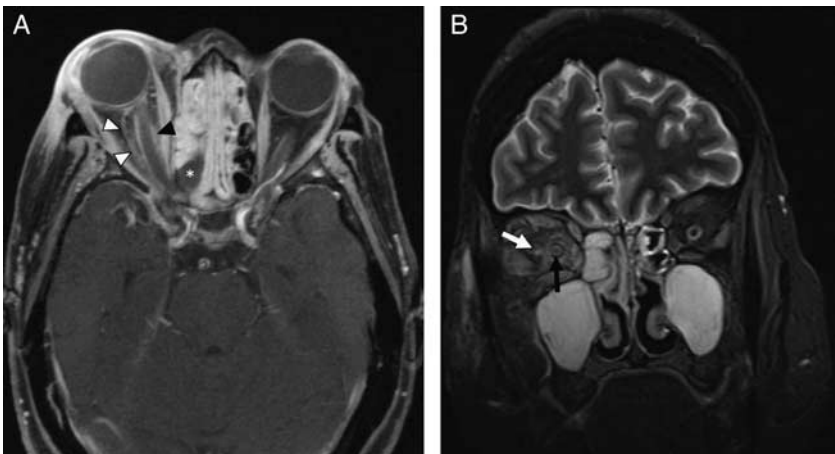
60-year-old woman with CLL was admitted for febrile neutropenia developed right eye chemosis, periorbital edema, and proptosis. She was taken urgently for orbital extenteration, which revealed invasive fungal disease. Axial T1-weighted contrast-enhanced fat-saturated MRI (A) demonstrates absent enhancement of a right posterior ethmoid air cell (white asterisk) as well as heterogenous enhancement of the right optic nerve sheath (black arrow head) and intraconal fat (white arrow heads). Coronal T2-weighted MRI (B) demonstrates T2 hyperintensity of the right optic nerve (black arrow) and intraorbital fat (white arrow) consistent with orbital spread. CLL indicates chronic lymphocytic leukemia; MRI, magnetic resonance imaging.
